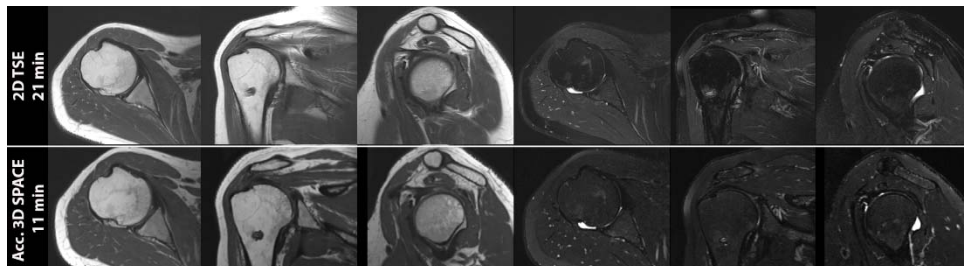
2D and 3D MRI of the shoulder in a 38-year-old man. Top row: 2D TSE protocol including axial, coronal and sagittal intermediate-weighted and fat-saturated T2-weighted images. Bottom row: Corresponding axial, coronal, and sagittal reconstructions of one intermediate-weighted and one fat-saturated T2-weighted accelerated 3D SPACE pulse sequence. The total acquisition time of the 2D and 3D protocol is given.
